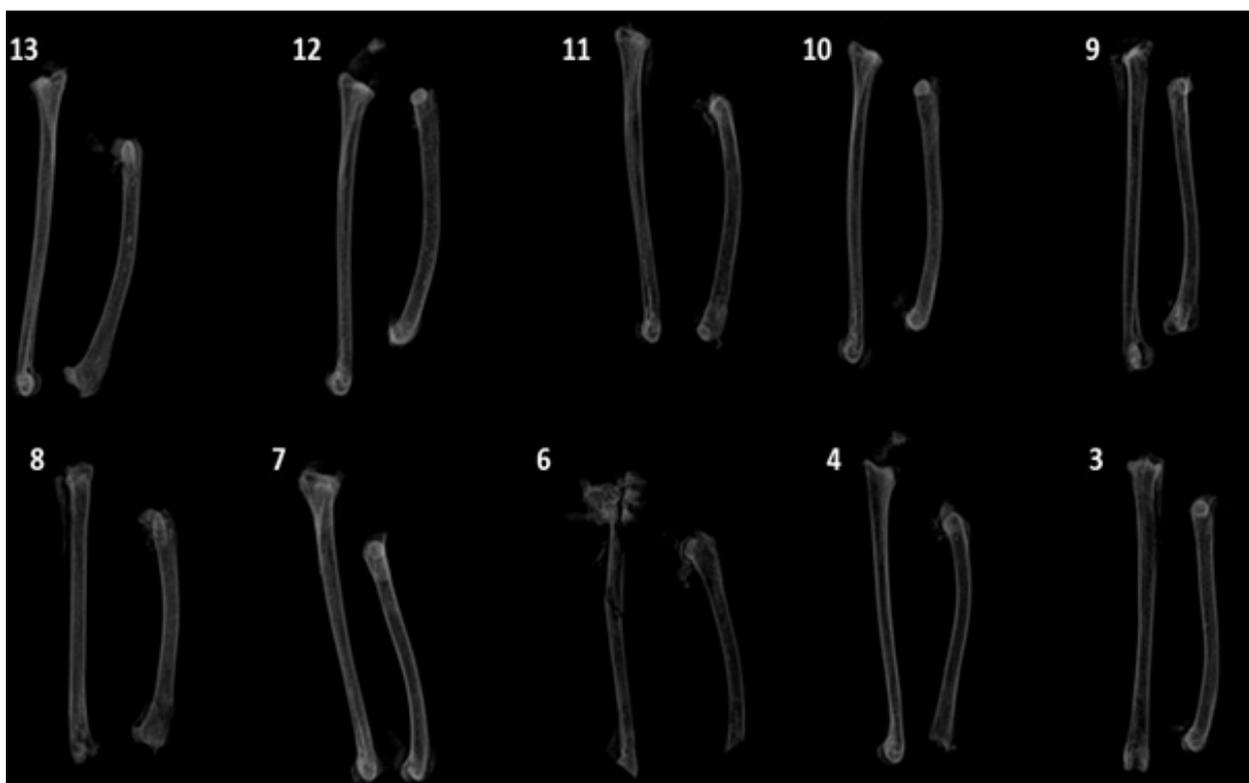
Radiographic evaluation of the long bones (femurs and tibiotarsi) of Japanese quail. The degree of moderate osteopenia was the most predominant. The numbers 3, 4, 6, 7, 8, 9, 10, 11, 12 and 13 represent the quails evaluated.
